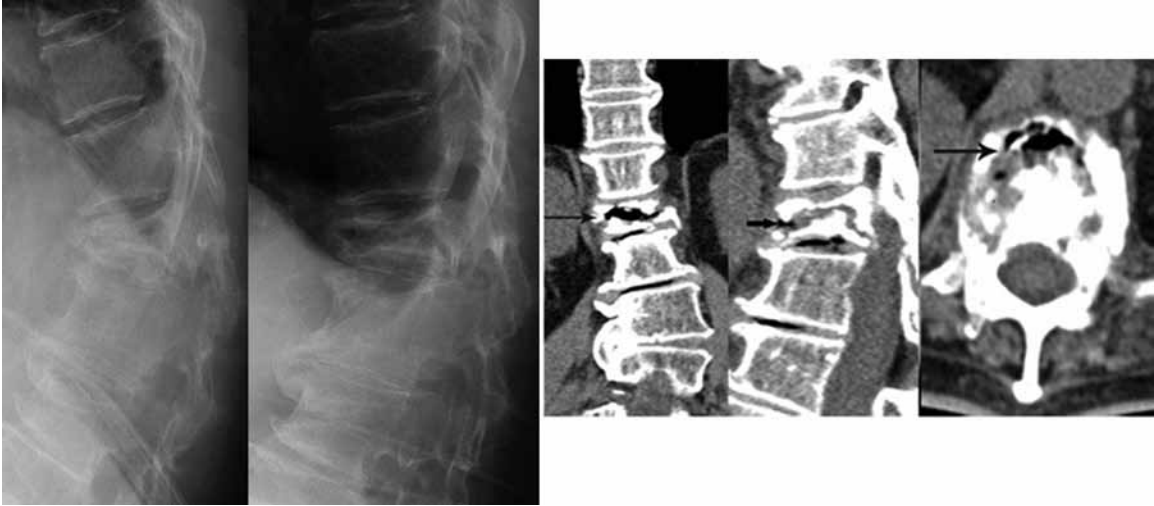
Six months after the initial injury, severe vertebral collapse and dynamic mobile fracture of the T12 vertebra were identified. CT scans showed an intravertebral vacuum cleft, sclerosis, and defect of the peripheral cortex, including the posterior cortex of the affected vertebral body.
